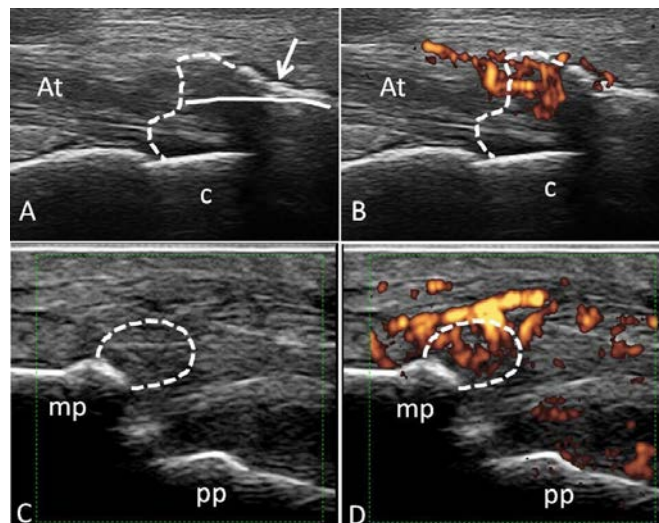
Psoriatic arthritis. Longitudinal scan of Achilles (A and B) and extensor digitorum (C and D) enthesal insertions, in B-mode and power Doppler ultrasound. (A and B) Achilles enthesitis. The dashed line represents 2-mm distance around the bony surface of the enthesitis that considers the pathological presence of the enthesophyte (arrow). The solid line represents the border of the enthesitis area without the enthesophyte. (C and D) Finger extensor enthesitis at the base of the middle phalanx (mp). The dashed line represents 2-mm distance around the bony surface of the enthesitis. At, Achilles tendon; c, calcaneal bone; pp, proximal phalanx.
